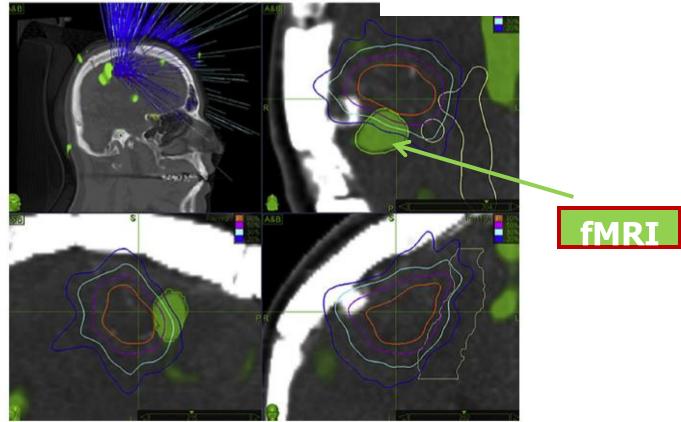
Stereotactic radiosurgery treatment plans developed without (top panels) and with (bottom panels) the functional structures and fibre pathways considered as organs at risk in the optimisation process, for a patient with World Health Organization grade II astrocytoma plotted in axial, coronal and sagittal planes. The configuration of the beams and the motor cortex (green) derived from functional magnetic resonance imaging are also depicted. In this unconventional case, because the glioma directly abutted the motor cortex, the authors felt the dose could only be modestly reduced from 2100 to 1900 cGy and therefore the biologically equivalent dose was calculated and delivered in three fractions. Reproduced with permission from [60].
